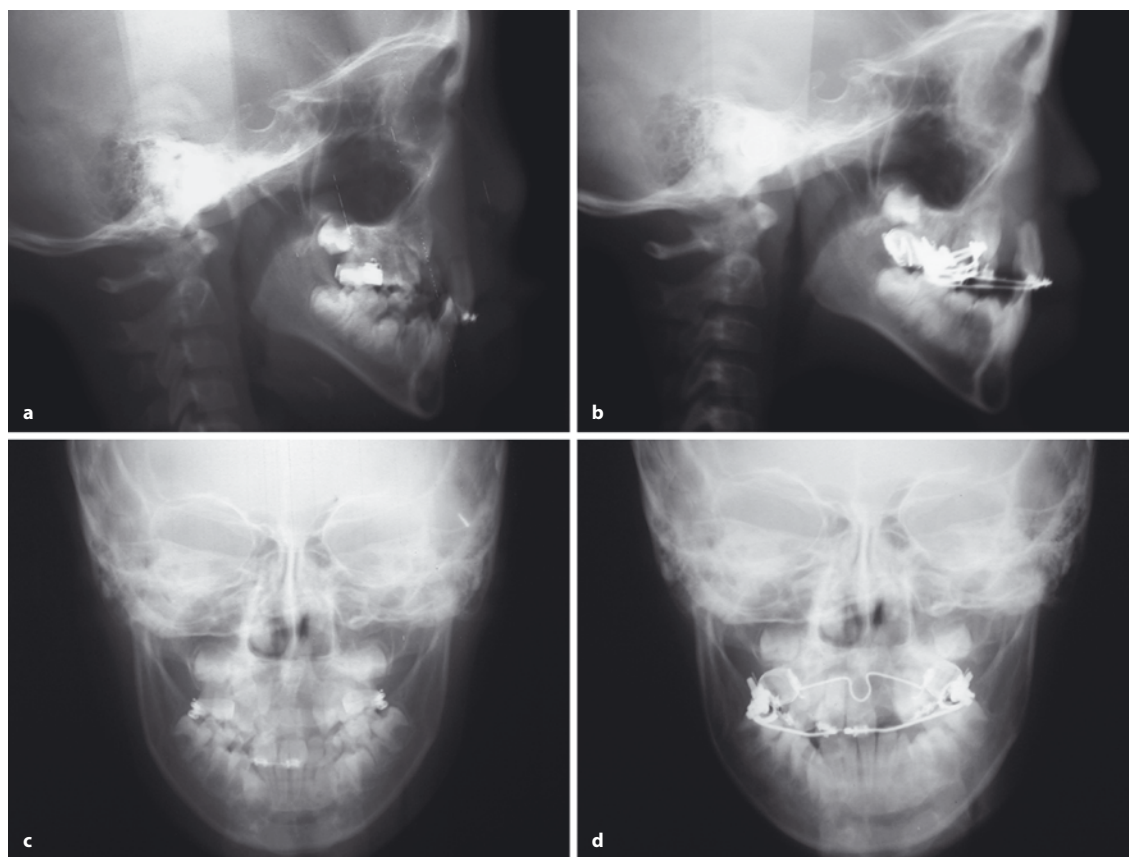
a–d. The cephalometric radiographs of the same patient in Fig. 24.7. a, b the lateral cephalogram before and after premaxillary orthopedic intrusion. c, d The posteroanterior
